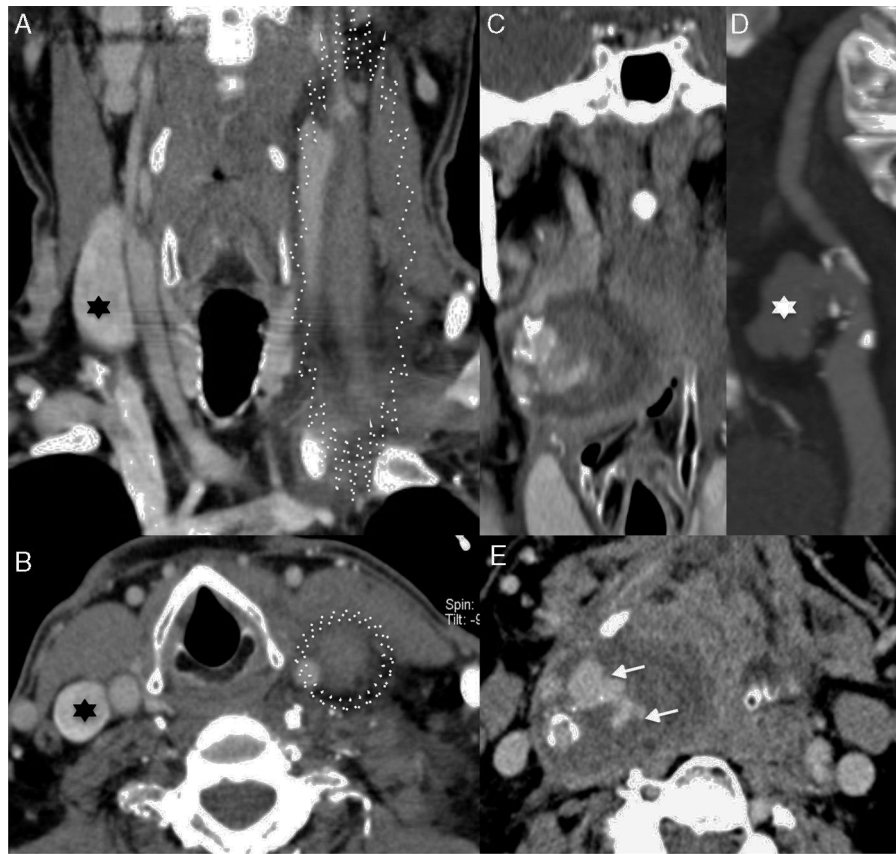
Vascular complications. (A) Computed tomography (CT), coronal section with IV contrast. (B) CT, axial section with IV contrast. (A and B) *Thrombophlebitis of the internal jugular vein*. Observe the absence of filling and poor definition of the left internal jugular vein (dotted silhouette), comparatively with the contralateral internal jugular vein (black asterisk). (C) CT, coronal section with IV contrast. (D) CT, sagittal oblique reconstruction of maximum pixel intensity (MPI). (E) CT, axial section with IV contrast. Patient with a history of gastroenteritis hospitalized due to parapharyngeal mass and dyspnea. She had a large aneurysm (asterisk in D) of the internal carotid artery with signs of rupture (white arrows in E). The microbiological study confirmed the diagnosis of *mycotic aneurysm* due to *Salmonella*.
